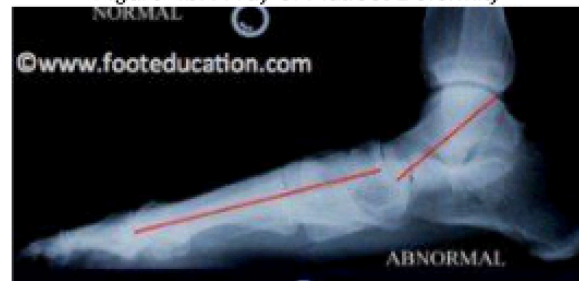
X-ray of Flatfoot Deformity
